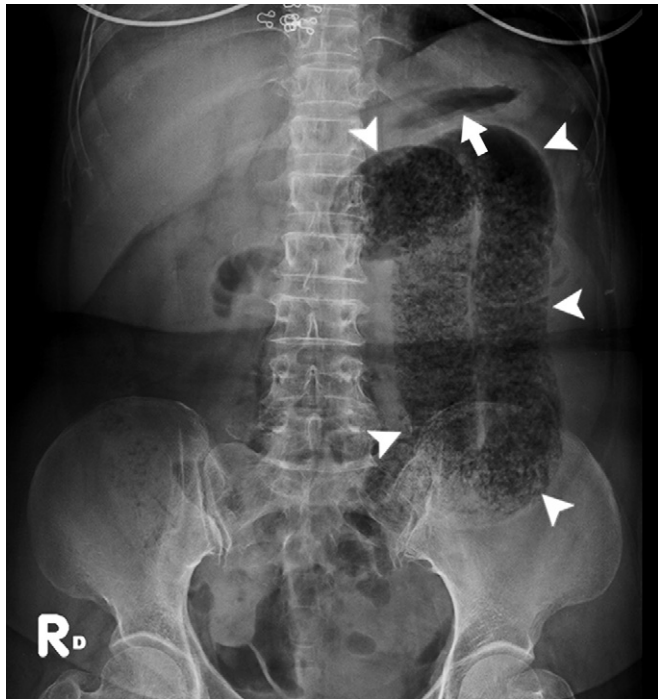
Anteroposterior plain abdominal radiograph shows dilated saclike small bowel loops (arrows) in the left abdomen, with a mass effect that displaced the greater curvature of the stomach (arrowheads).
